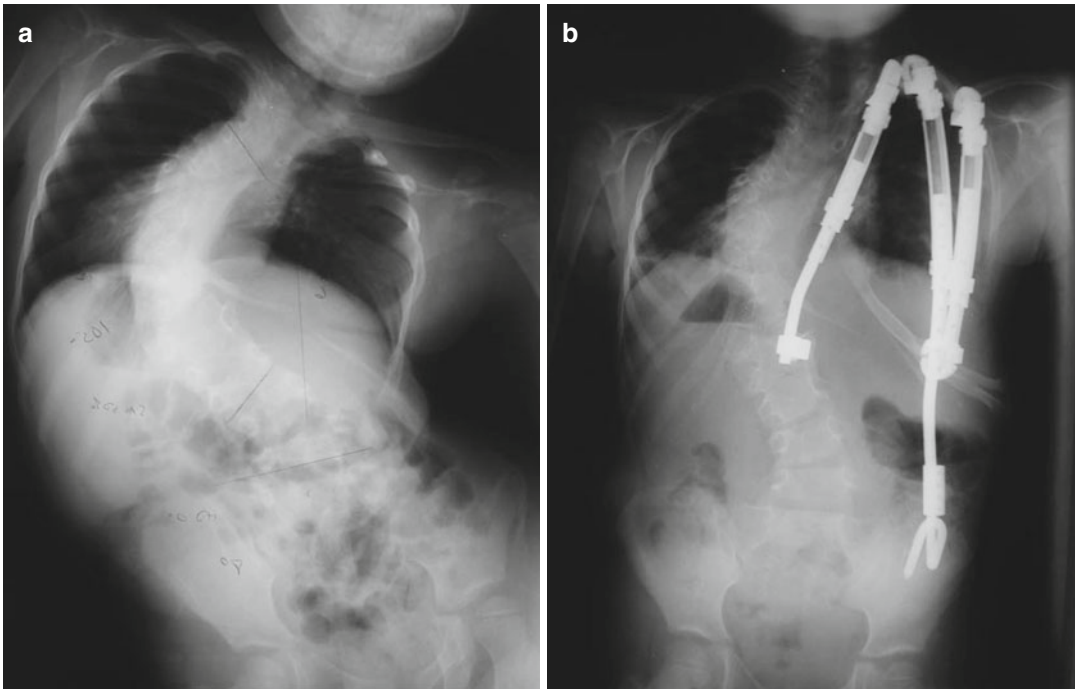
(a) Preoperative x-rays of a rib absence patient. (b) Postoperative x-rays VEPTR procedure for rib absence
